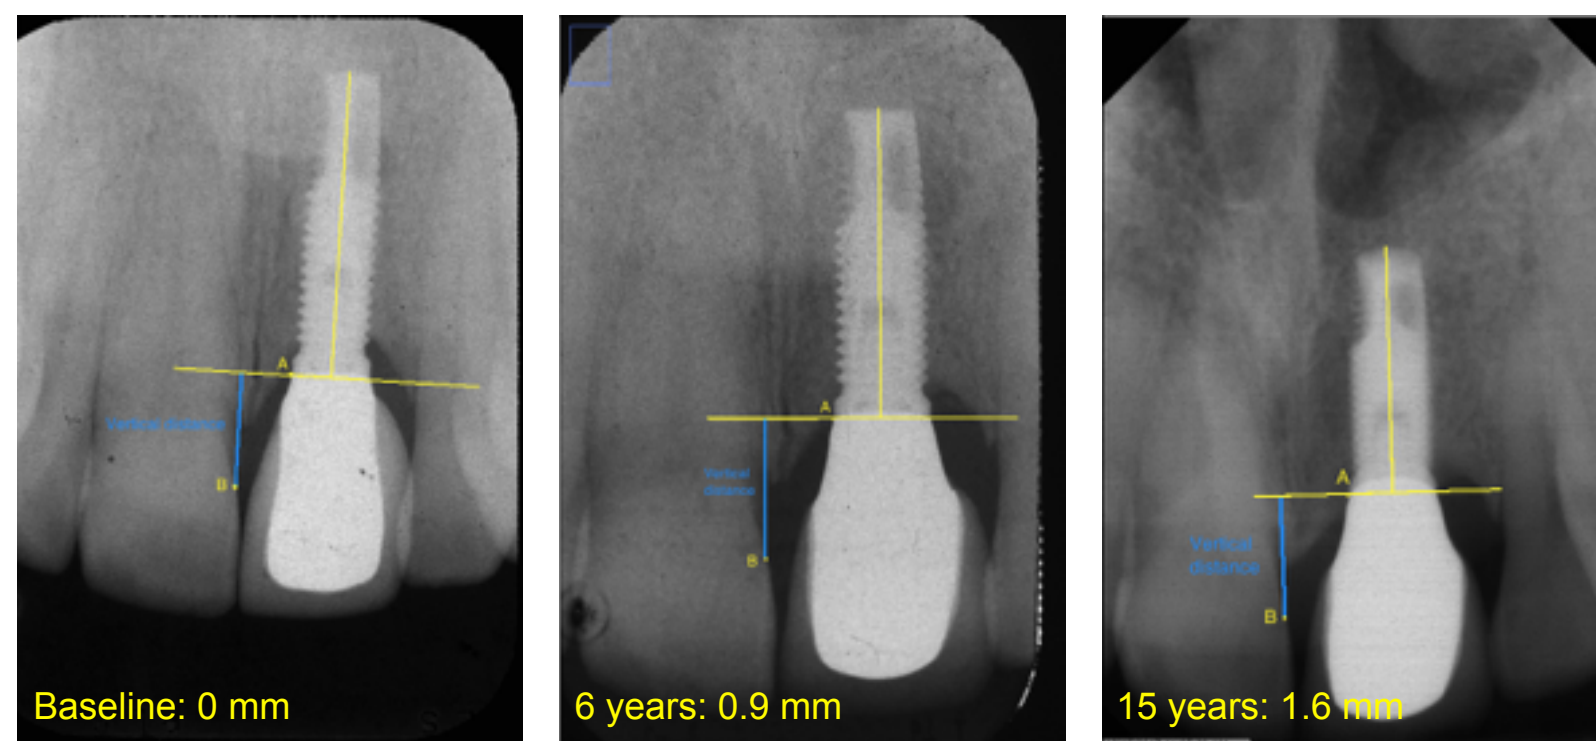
Radiographic assessments of infra-occlusion over time. (A) implant-abutment junction, (B) CEJ of the adjacent tooth.
